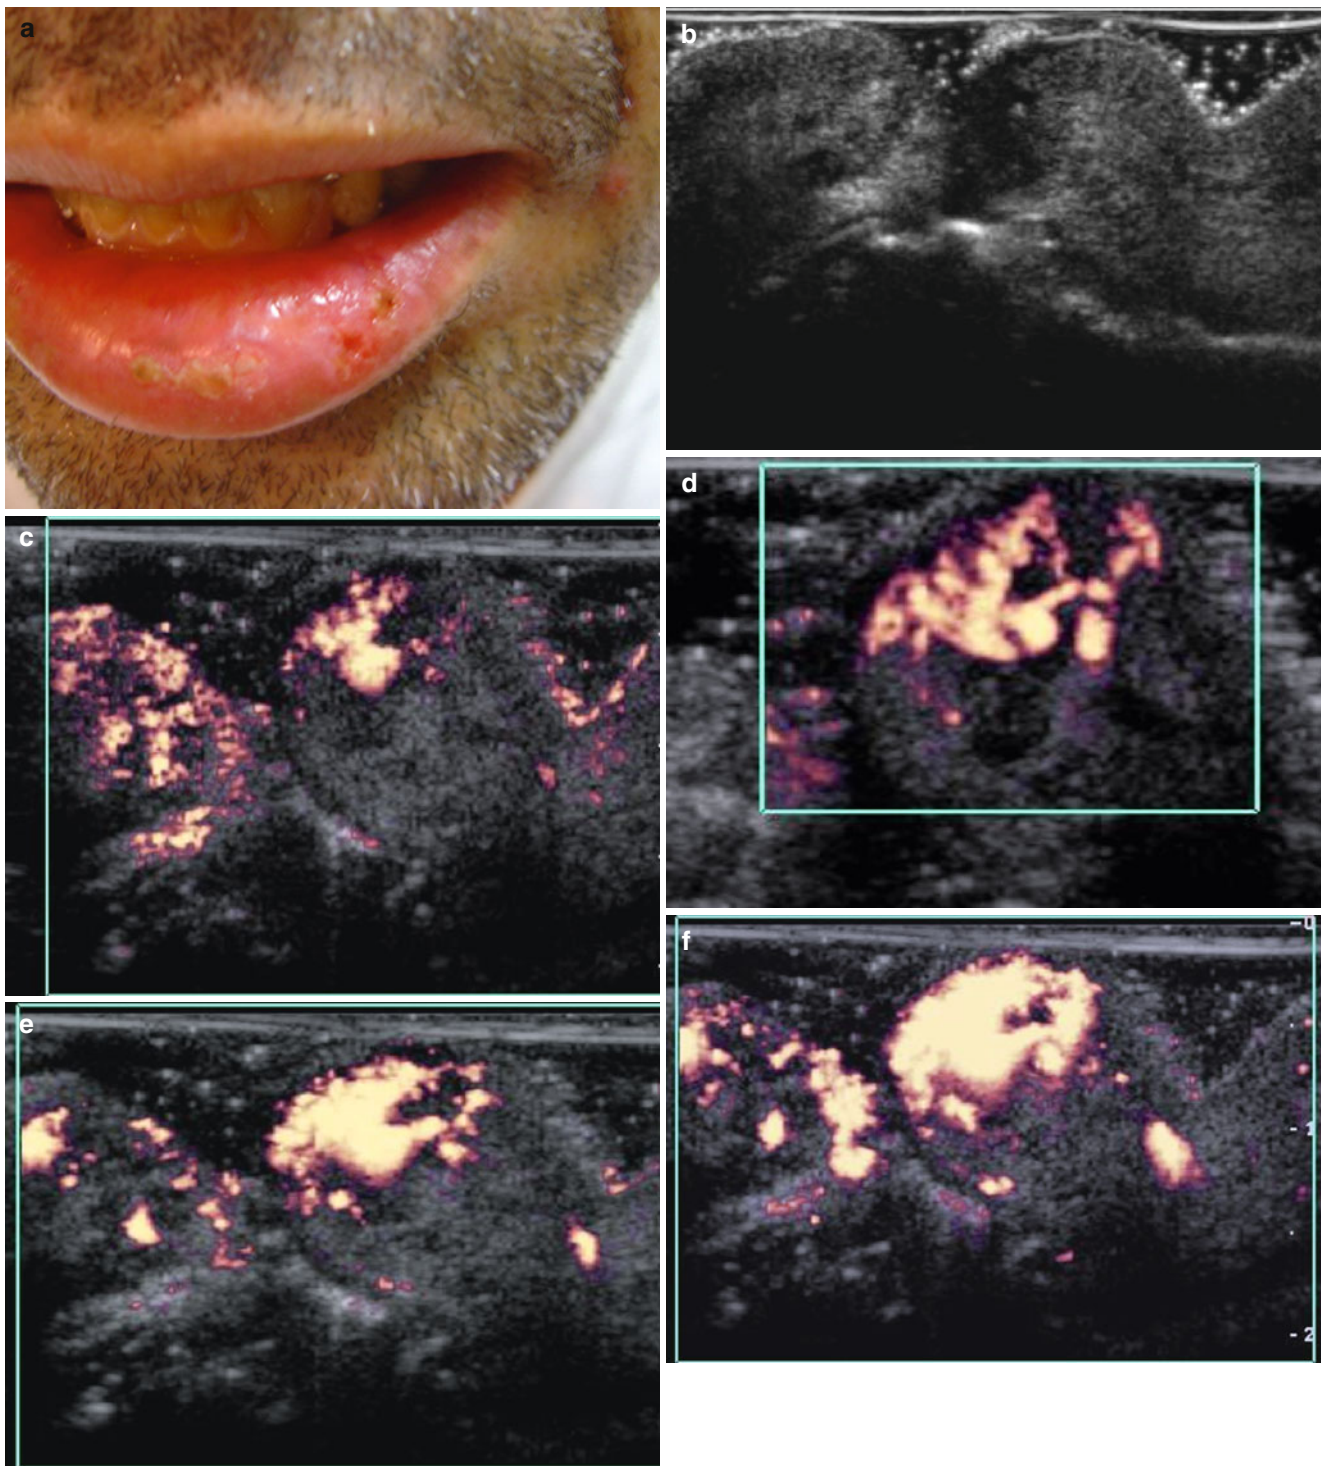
(a) Lower lip squamous cell carcinoma. (b) Grey scale ultrasound image. (c, d) Power Doppler ultrasound image before contrast—some vessels seen in central region. (e, f) Power Doppler ultrasound image after contrast—lesion better seen after contrast, hypervascularized
